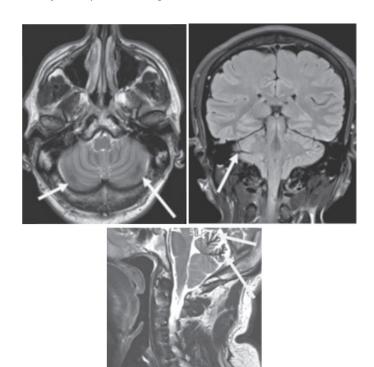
Showing area of black rimmed hypointensity along the surface of the cerebellum bilaterally T2, axial, coronal and sagittal MRI views respectively
